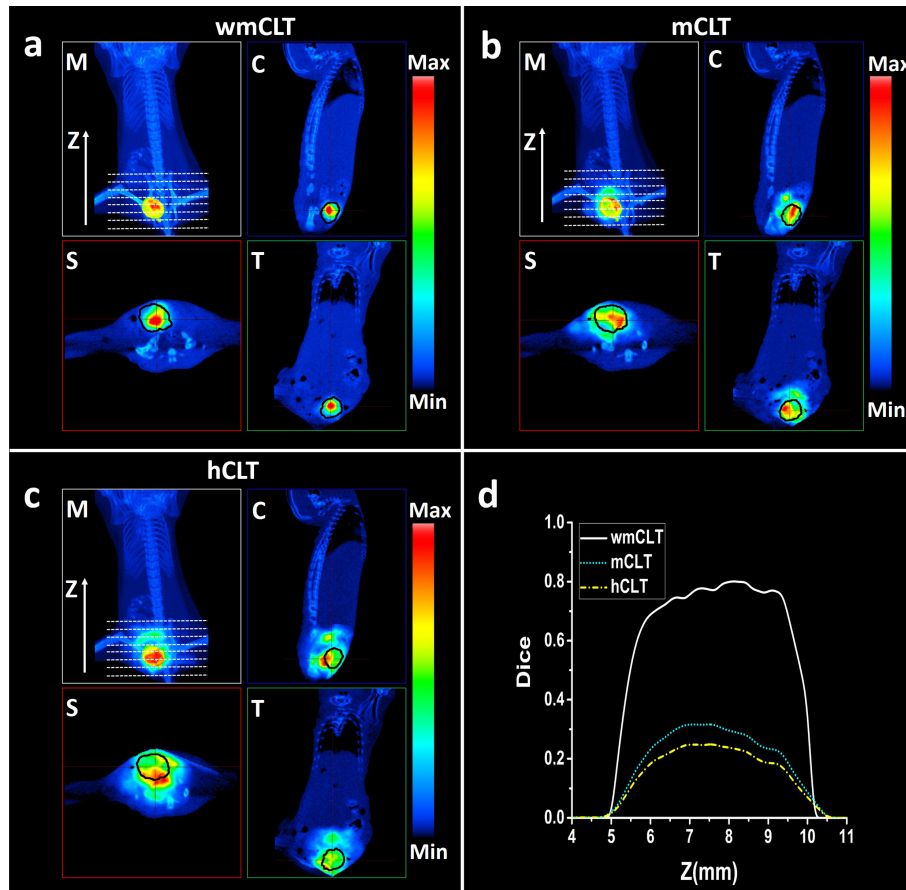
The bladder reconstruction results. (a)-(c) are the results of our proposed wmCLT, traditional mCLT and hCLT respectively; in each figure, it also includes the 3D maximum intensity projection view (M), coronal view (C) and sagittal view (S) and the transversal view (T). (d) is the Dice index line of the fist 100 CT slices (as the white dotted lines in the 3D maximum intensity projection view (M) show), where the white solid line, blue short dotted line and the yellow short dash-dotted line represent the wmCLT, mCLT, and hCLT.
